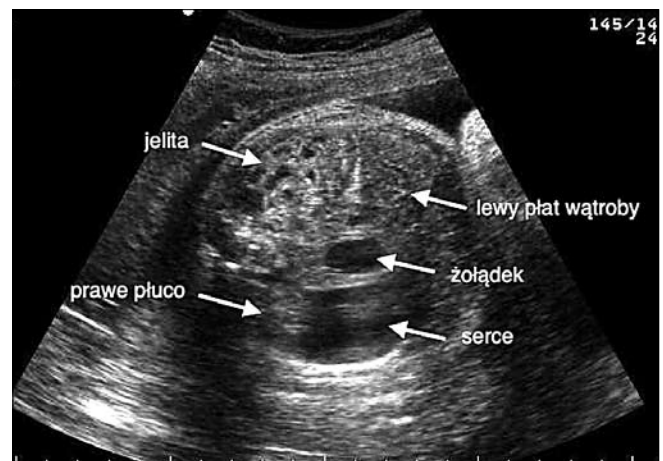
Sonographic cross-section of foetal thorax at 36 weeks gestation.
